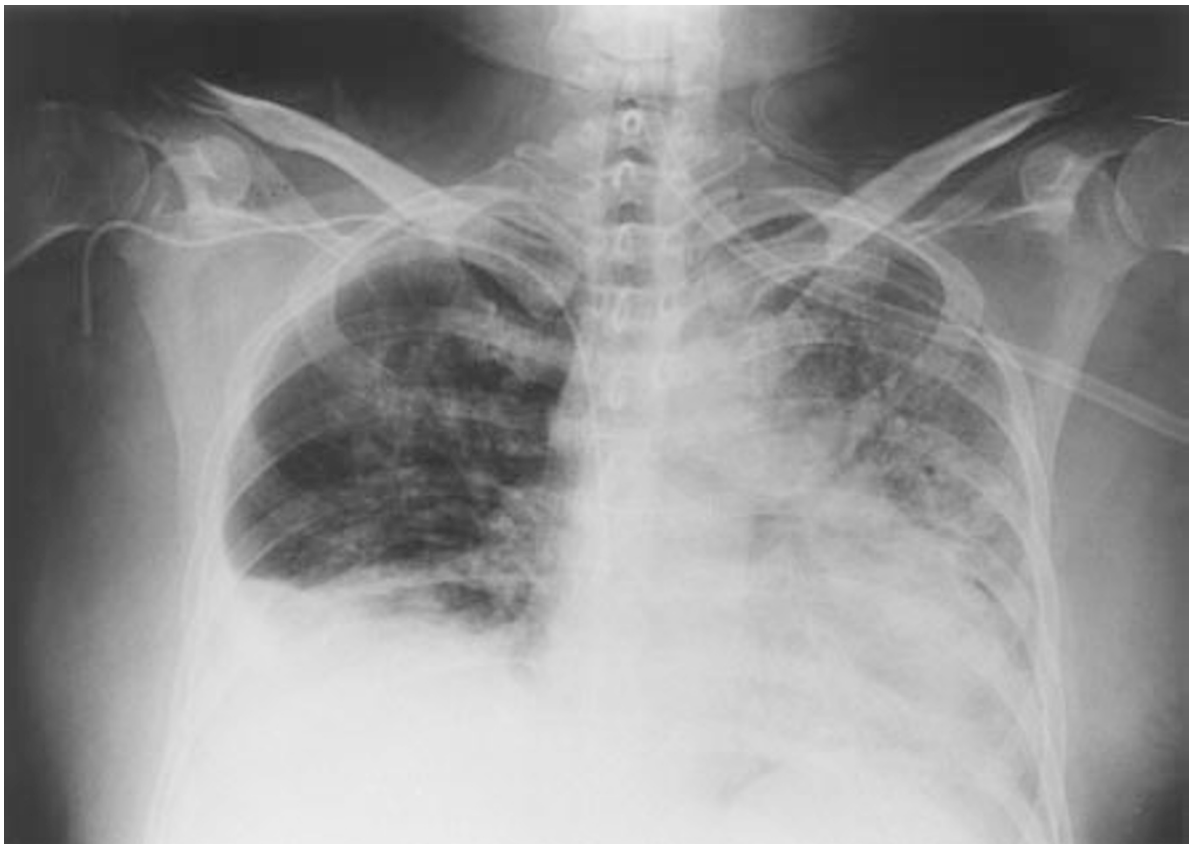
Chest radiograph on day +160. The radiograph shows bilateral diffuse interstitial infiltrates.
